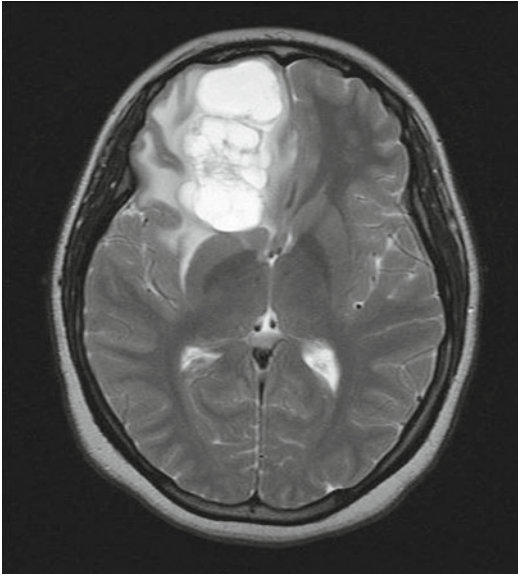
Contrast-enhanced mass lesion on magnetic resonance imaging (MRI)
